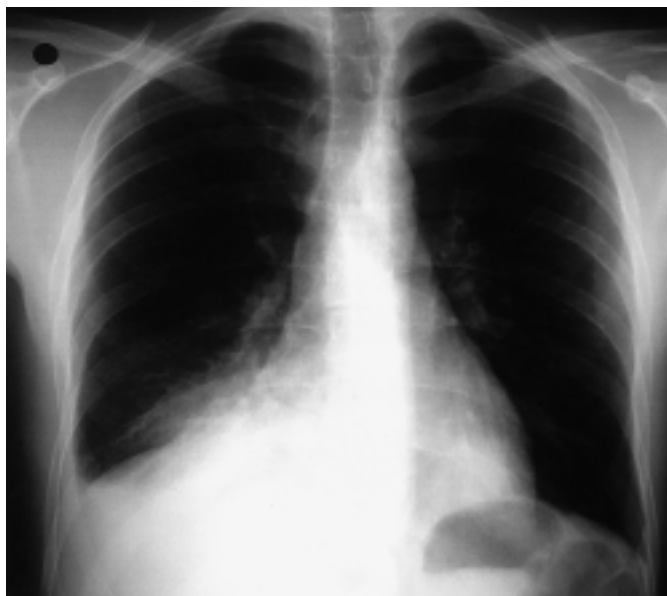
Posterioranterior chest radiograph shows right middle and lower lobe infiltrates and accompanying ipsilateral effusion caused by accidental aspiration of a liquid hydrocarbon mixture.
